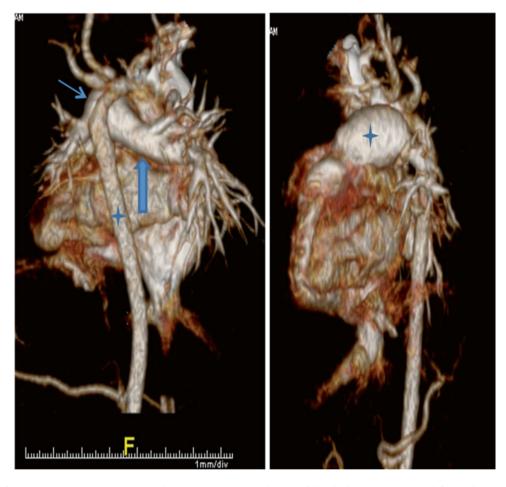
Use of CTA reconstruction to evaluate pulmonary hypertension in infants with BPD. *Right*: lateral view showing enlarged main pulmonary artery (PA) (*star*); *left*: posterior view showing enlarged
